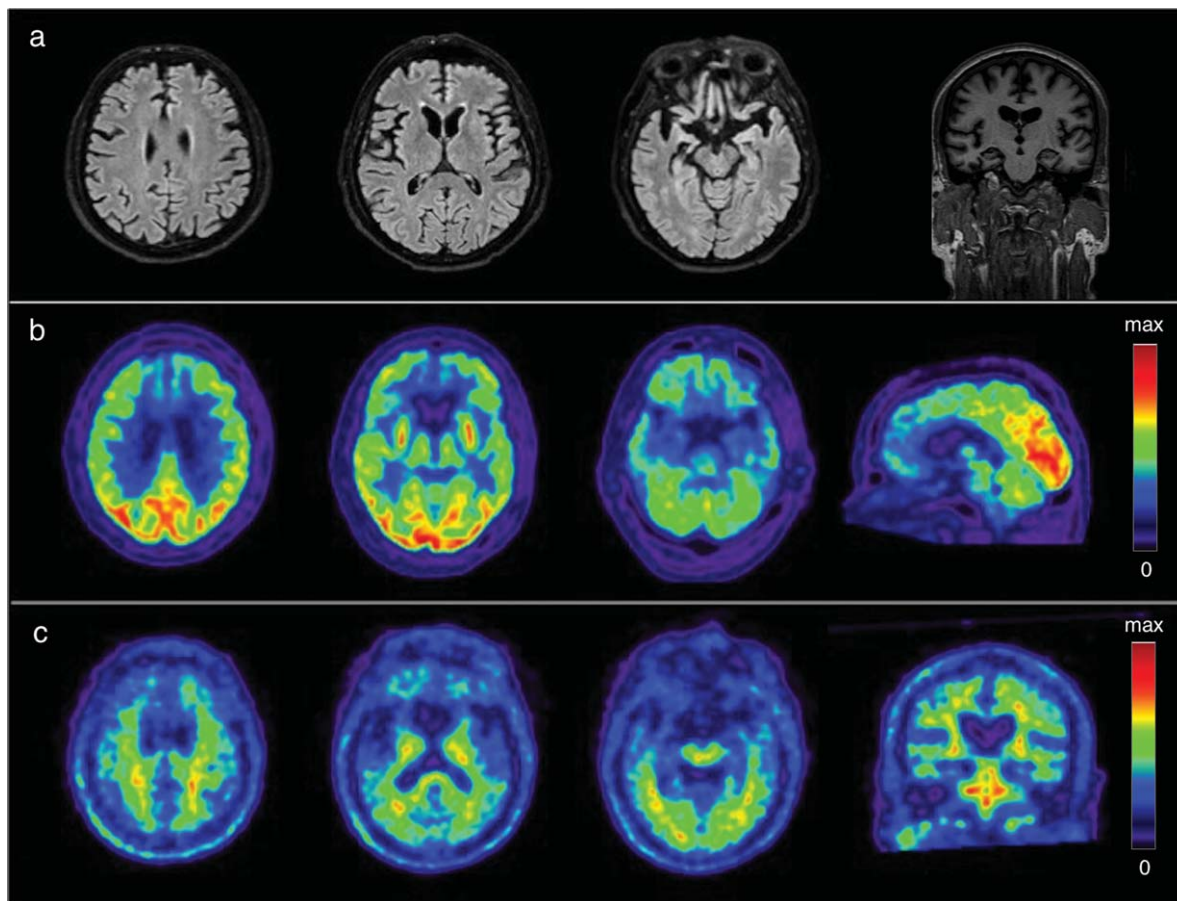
Neuroimaging data a) MRI, axial T2-weighted fluid-attenuated inversion recovery images and coronal T1-weighted image: no vascular lesions, evidence of cortical and hippocampal atrophy; b) [ $^{18}\text{F}$ ]FDG-PET: severe hypometabolism in frontal lobes, hippocampi and caudate nuclei; c) [ $^{18}\text{F}$ ]Florbetapir PET: no tracer retention in grey matter.
